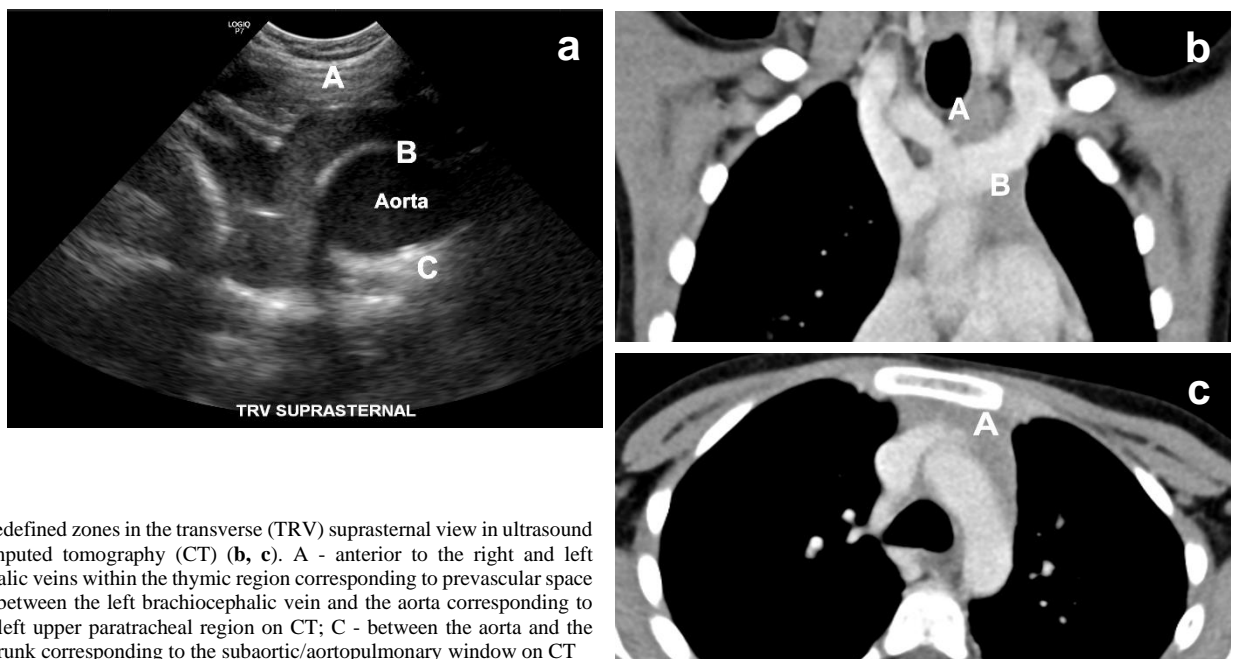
Predefined zones in the transverse (TRV) suprasternal view in ultrasound (a) and computed tomography (CT) (b, c). A - anterior to the right and left brachiocephalic veins within the thymic region corresponding to prevascular space on CT; B - between the left brachiocephalic vein and the aorta corresponding to prevascular/left upper paratracheal region on CT; C - between the aorta and the pulmonary trunk corresponding to the subaortic/aortopulmonary window on CT
